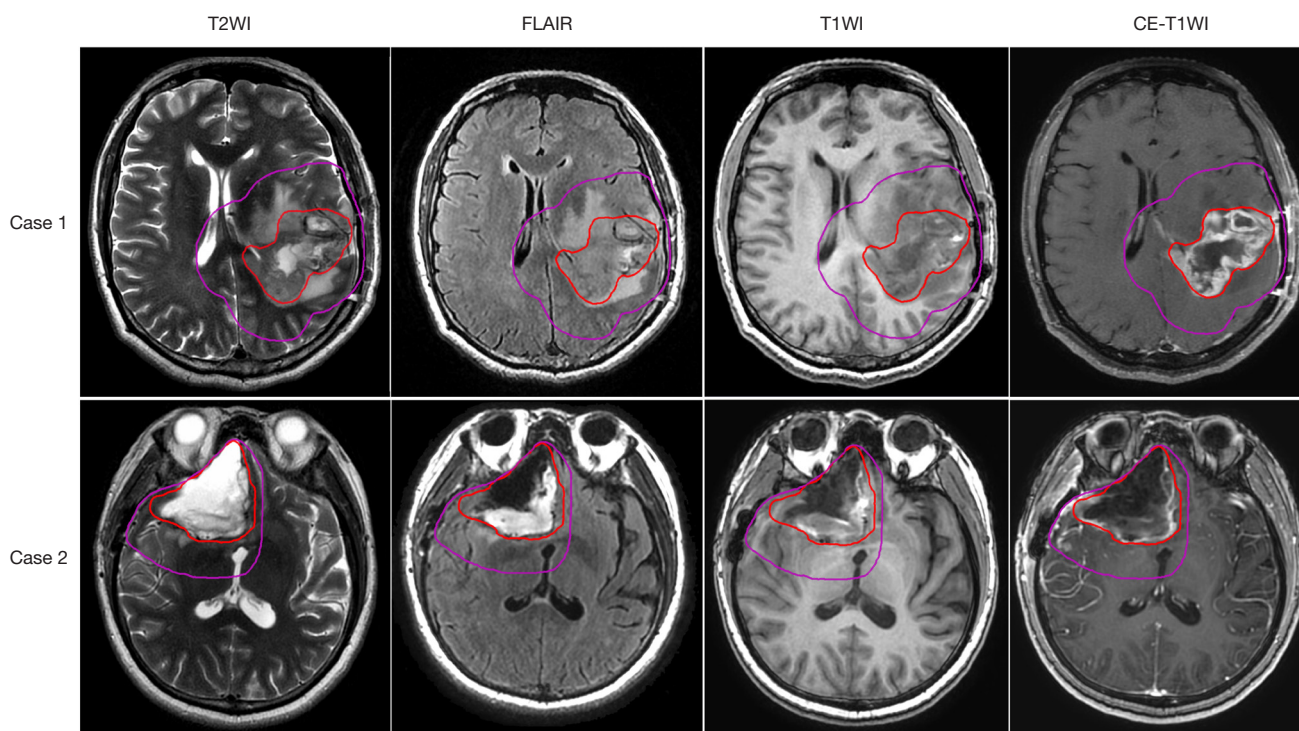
Examples for GTV and CTV. GTV is contoured in red, and CTV is contoured in purple. Each row represents MRI images for 1 patient; from left to right: T2WI, FLAIR, T1WI, and CE-T1WI. T2WI, T2-weighted imaging; FLAIR, fluid-attenuated inversion recovery; T1WI, T1-weighted imaging; CE-T1WI, contrast-enhanced T1-weighted imaging; GTV, gross tumor volume; CTV, clinical target volume; MRI, magnetic resonance imaging.
